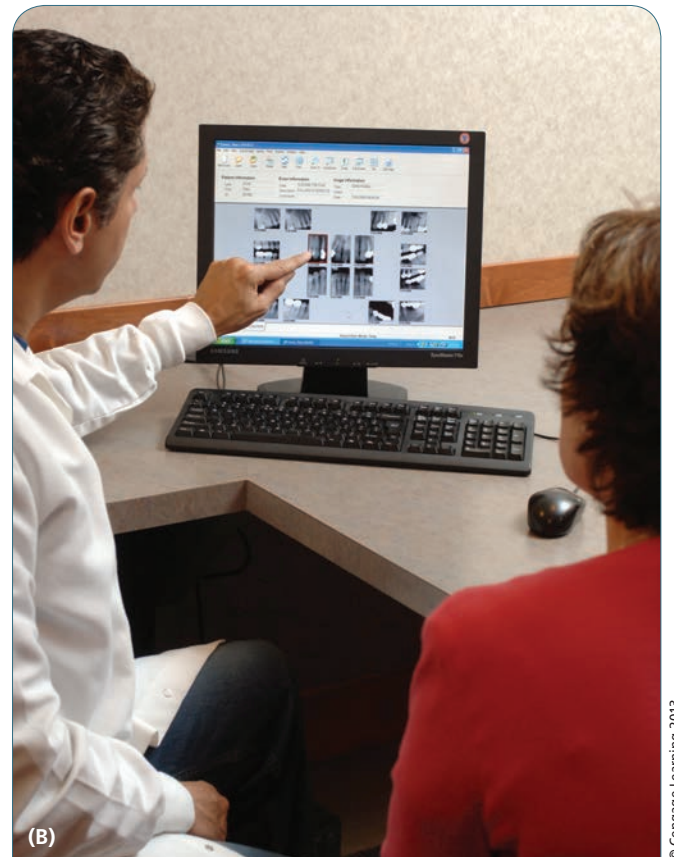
Everything needed for cosmetic case presentation: medical/dental history. (A) Photographs. (B) X-rays, panoramic x-ray. (C) Periodontal and restoration chart and occlusal evaluation.
